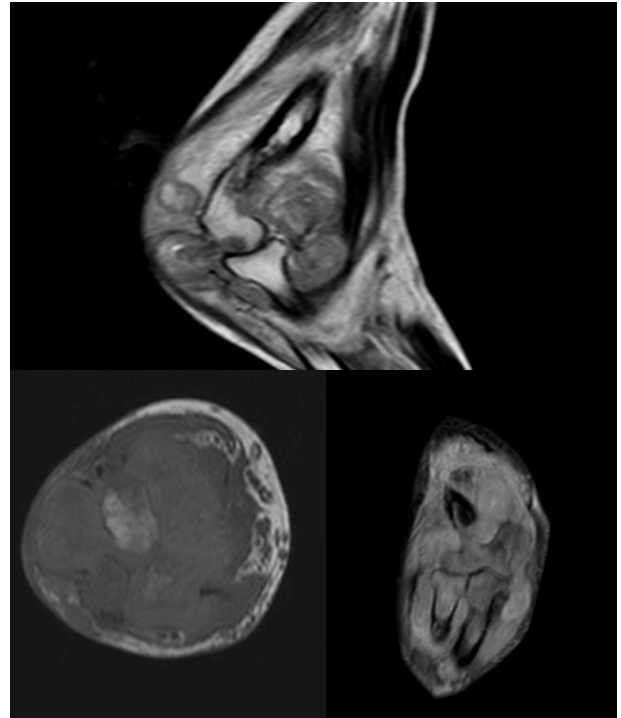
MRI images of the right elbow.
